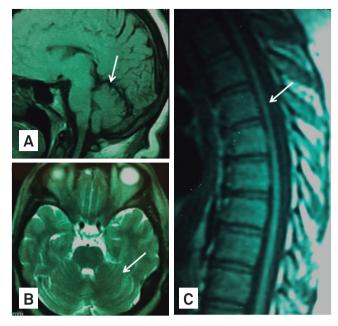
(A) Sagittal T1-weighted and axial T2-weighted brain MRI disclosing normal cerebellar volume, without atrophy, in a patient with Friedreich ataxia; (C) sagittal T1-weighted thoracic spine MRI of the same patient, showing atrophy of the spinal cord.
